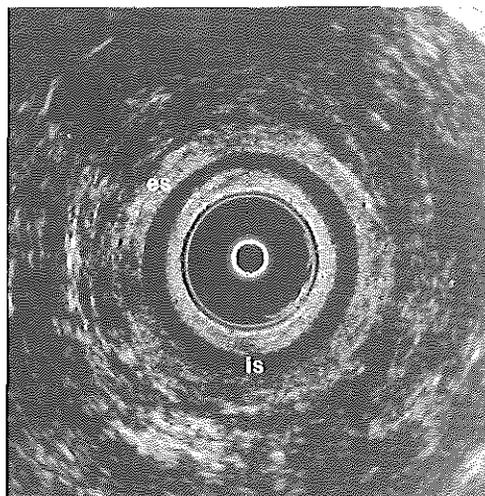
Axial endoanal sonography showing a normal sphincter complex: external sphincter (ES), internal sphincter (IS).
